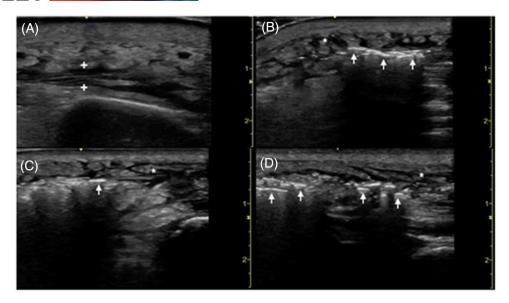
Point-of-care ultrasound of the affected right tibia in a transverse (A) plane demonstrating perifascial fluid accumulation (between plus symbols). Point-of-care ultrasound of the affected right foot in transverse (B,C) and longitudinal (D) planes demonstrating hyperechoic air foci (arrows) with dirty posterior shadowing representative of necrotizing fasciitis. Subcutaneous edema (asterisks) clinically consistent with overlying cellulitis
